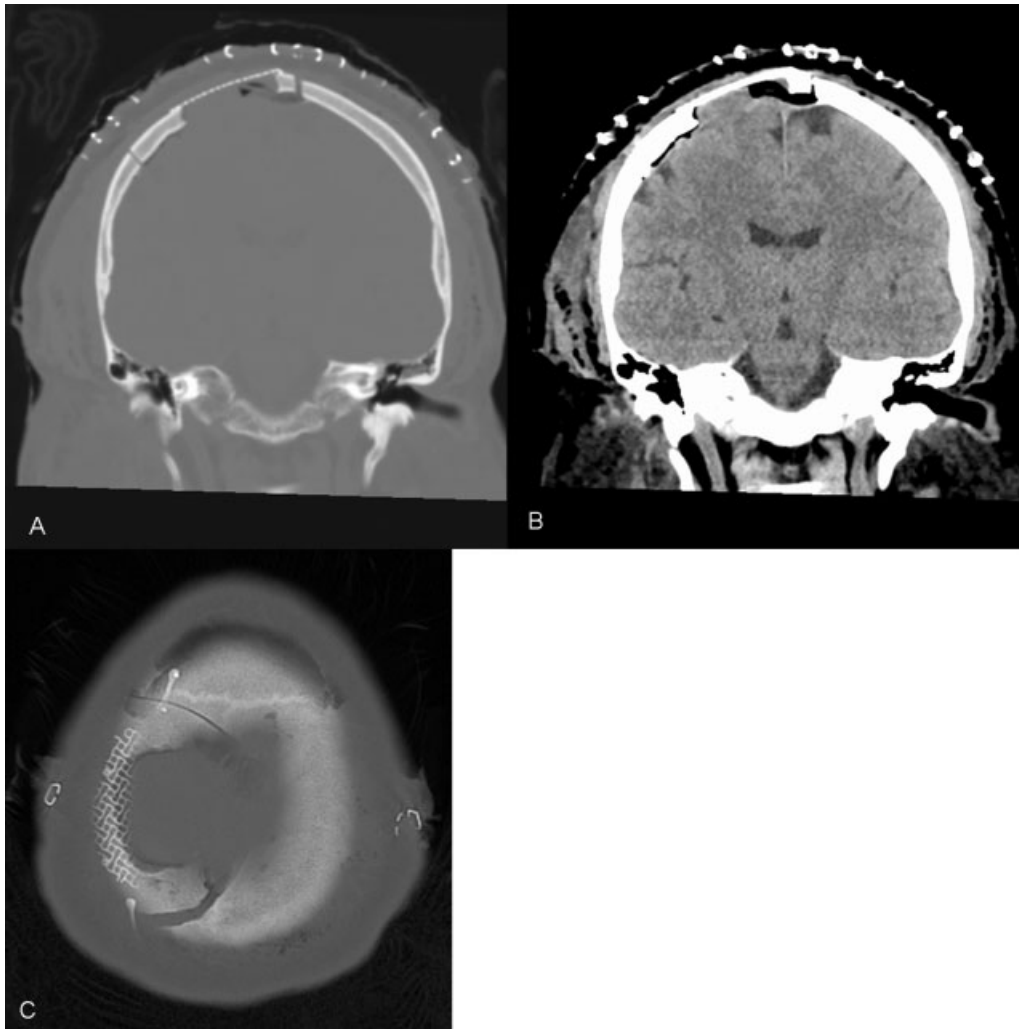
(C) A 3-mm axial bone window and coronal reformats in both (B) brain and (A) bone windows on postoperative CT. CT, computed tomography.
